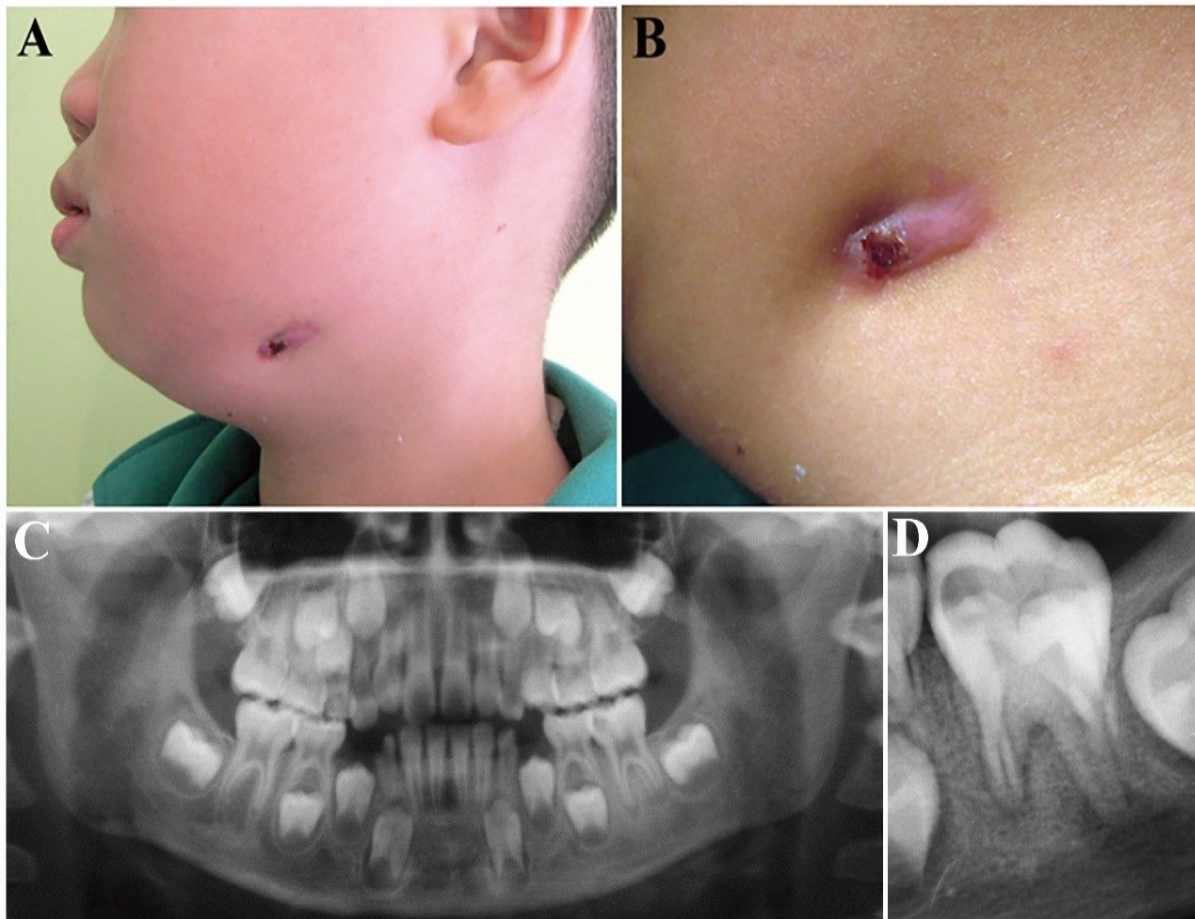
(A) Pre-operative view of the cutaneous sinus tract. Repetitive drainage and antibiotic therapy did not resolve the condition. (B) Magnified view of the cutaneous sinus tract. (C) Pre-operative panoramic view, showing a radiolucent lesion on the mesial aspect of the crown of tooth 36 extending to the mesial pulp horn, while the occlusal aspect of the crown was intact. (D) Periapical radiograph of tooth 36, revealing immature apices and an extended periapical radiolucency at the distal root.
